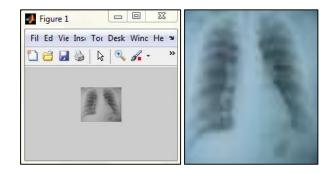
X-ray film of normal lung and its grayscale image
